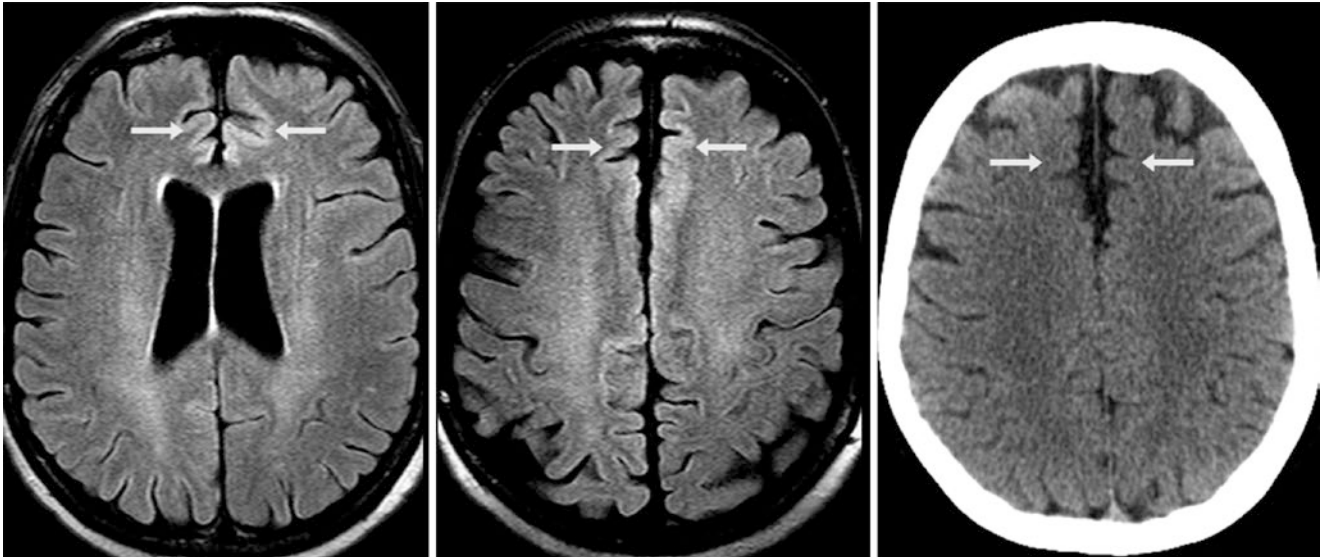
A 60-year-old with headaches underwent an otherwise normal 3 T MRI that demonstrates mildly hyperintense cortices of the orbitofrontal gyri (*arrows*) on FLAIR (*left and middle*). A nonenhanced CT (NECT) scan (*right*) depicts a normal appearance
